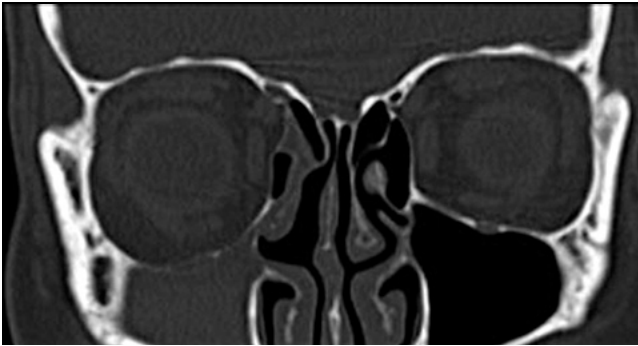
Preoperative CT scan (frontal view) showing inferior displacement of the orbital floor, lateralisation of the middle turbinate and opacification of the maxillary sinus.
